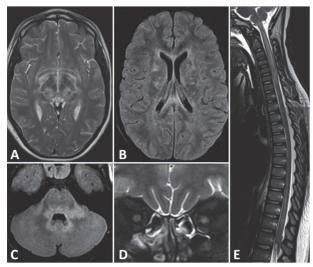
Brain, orbits, and spinal cord magnetic resonance imaging. (a) Axial T2. Diencephalic lesions. (b) Axial fluid-attenuated inversion recovery. Bihemispheric white matter and corpus callosum lesions. (c) Axial fluid-attenuated inversion recovery. Lesions in middle cerebellar peduncles and around the fourth ventricle. (d) Coronal T2 fat suppression. Bilateral optic nerve hypersignal. (e) Sagittal T2. Longitudinally extensive myelitis.
